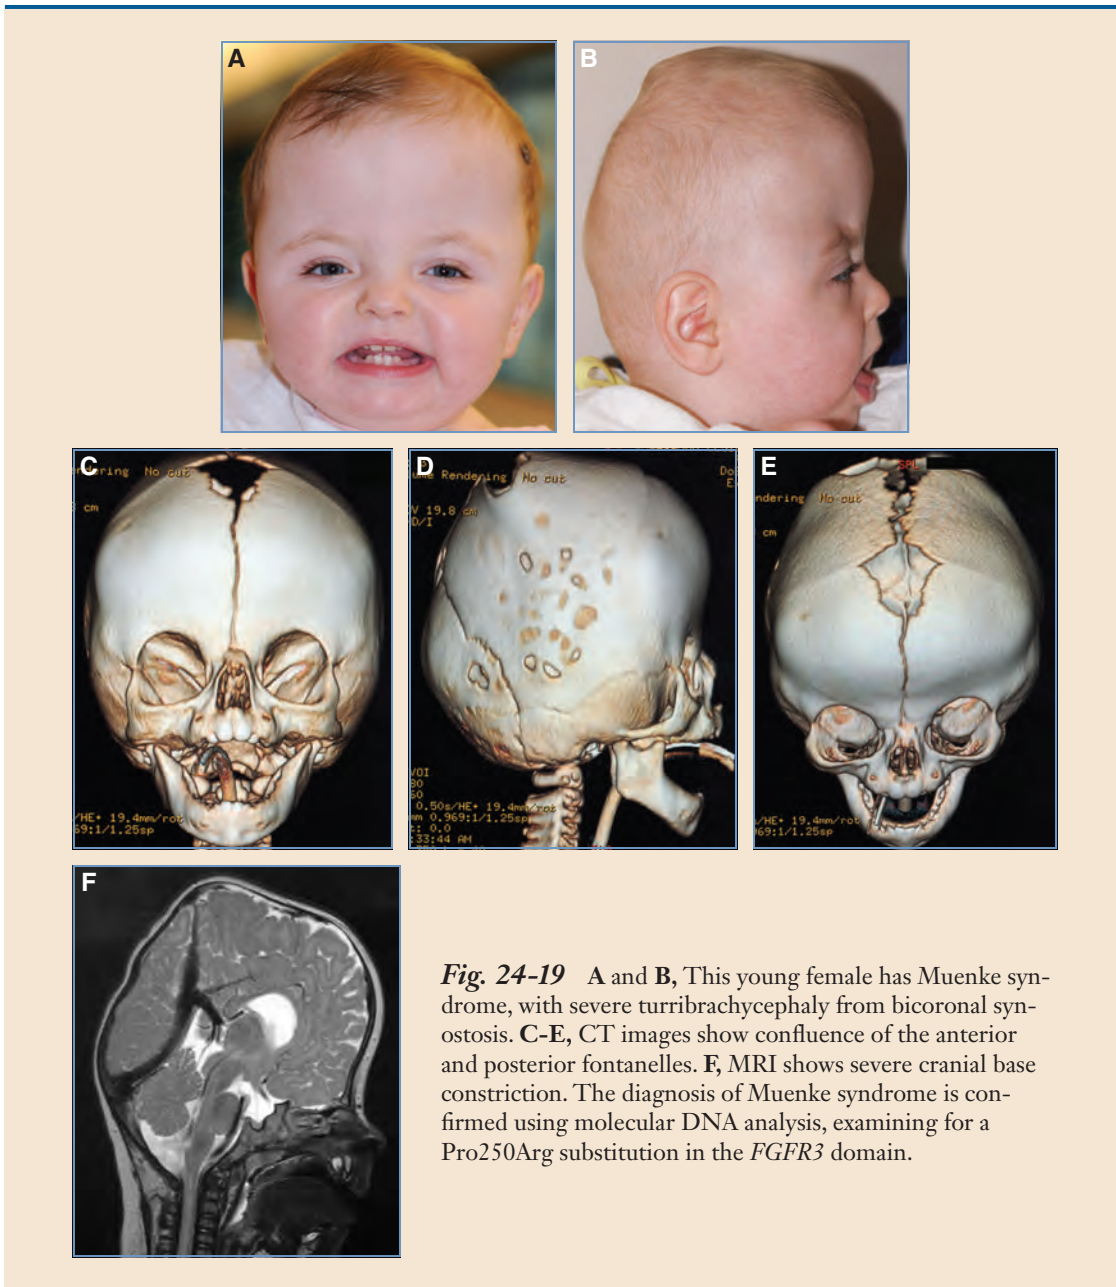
A and B, This young female has Muenke syndrome, with severe turribrachycephaly from bicoronal synostosis. C-E, CT images show confluence of the anterior and posterior fontanelles. F, MRI shows severe cranial base constriction. The diagnosis of Muenke syndrome is confirmed using molecular DNA analysis, examining for a Pro250Arg substitution in the *FGFR3* domain.
